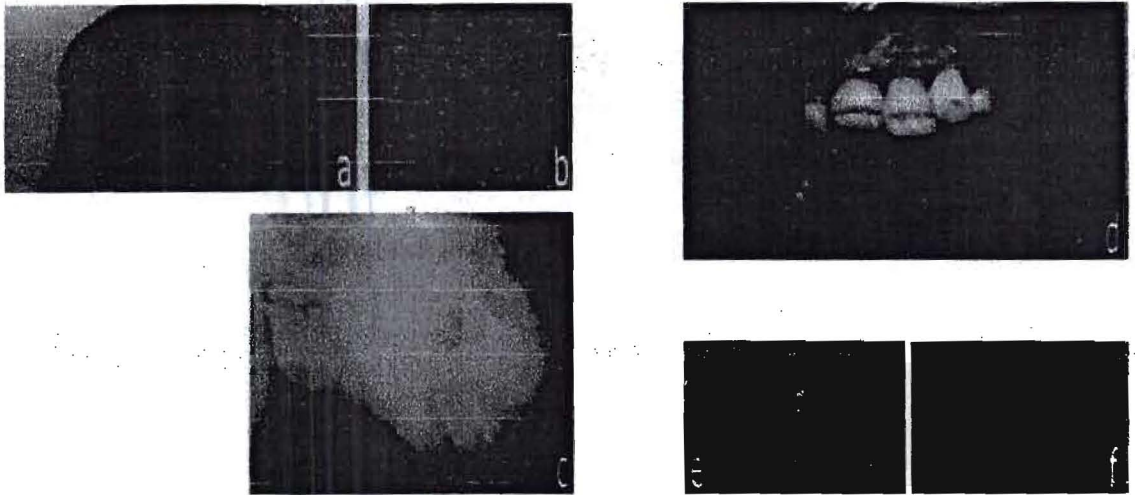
FTC morphological features: (a) and (b) show patients with large periarticular tumors around hips and shoulders; (c) Radiographic film of the right hip showing calcification in the soft tissues around the joint; (d) dental alteration: amelogenesis imperfecta; (e) and (f) important rhyzalysa on certain teeth and partial calcification on pulpar cavities showing bulbous and short racines.
